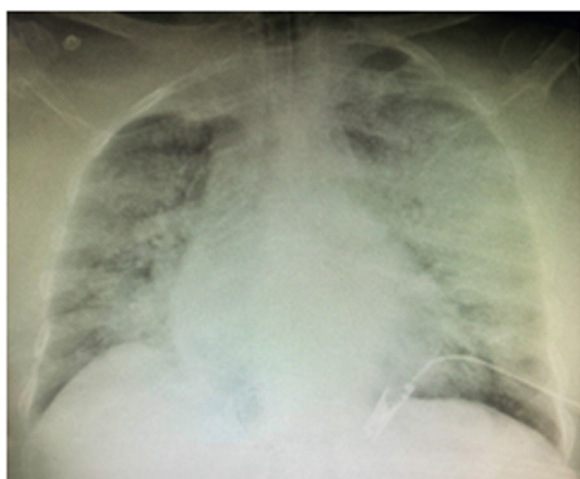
Diffuse ground-glass density image on posteroanterior chest radiography and computed tomography angiography
